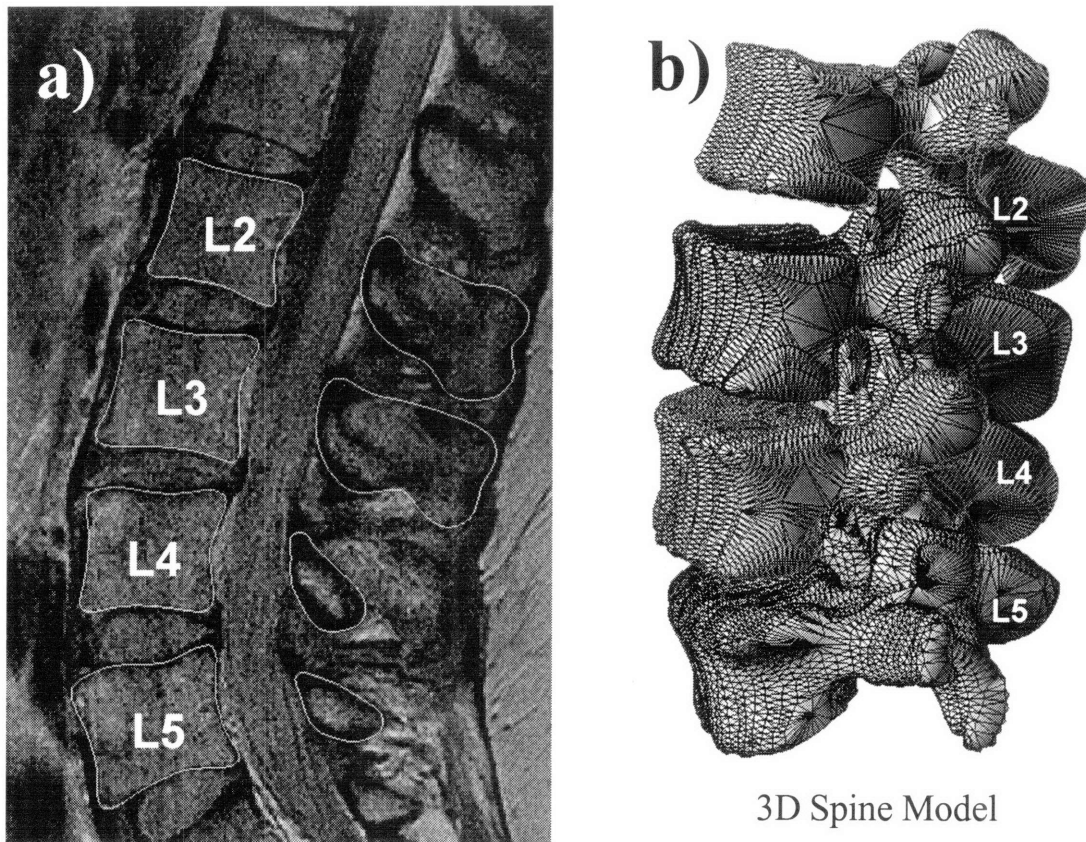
a) Contours of the vertebrae bodies was digitized with spline curves give the anatomy information of the lumbar spine. b) 3D mesh model can be generated from digitized contours of MRI layer by layer.
